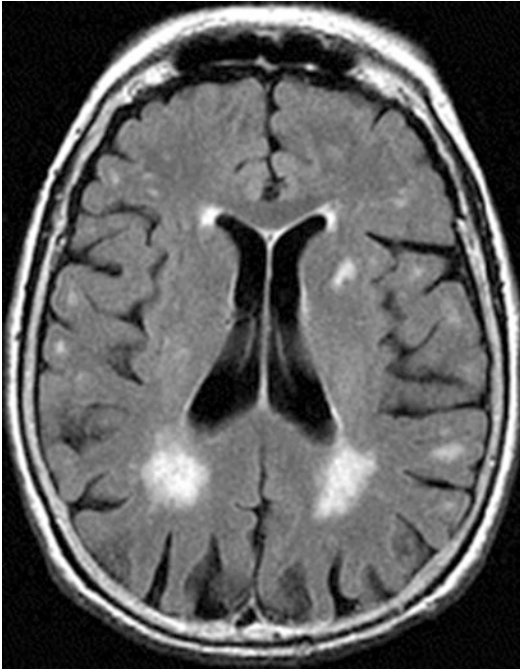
White matter hyperintensities in elderly women. Hyperintensities appear as “bright signals” (bright areas) on an MRI image
